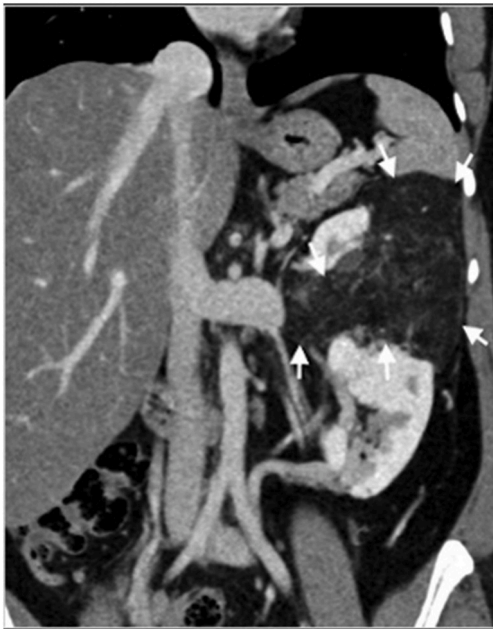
Pre-procedural Coronal CT with IV contrast in the venous phase demonstrating a hypodense, fat predominant, enhancing mass in the superior pole of the left crossed fused ectopic kidney, measuring 10 × 10 × 9.7 cm (arrows).
